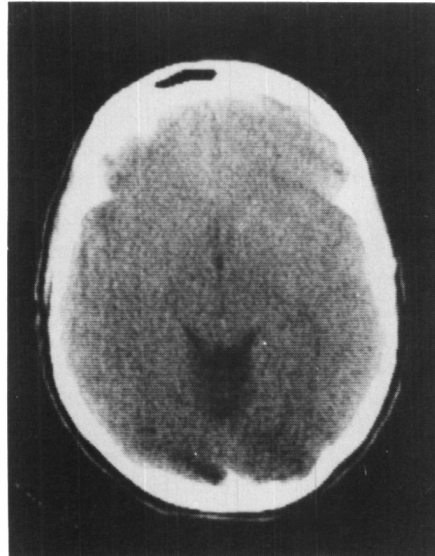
CT scan demonstrating enlarged posterior communicating cisterns and superior sulci in A (upper). Increased IVth ventricle, and severe cerebellar atrophy with foliae seen in entire cerebellar field in B (lower).
